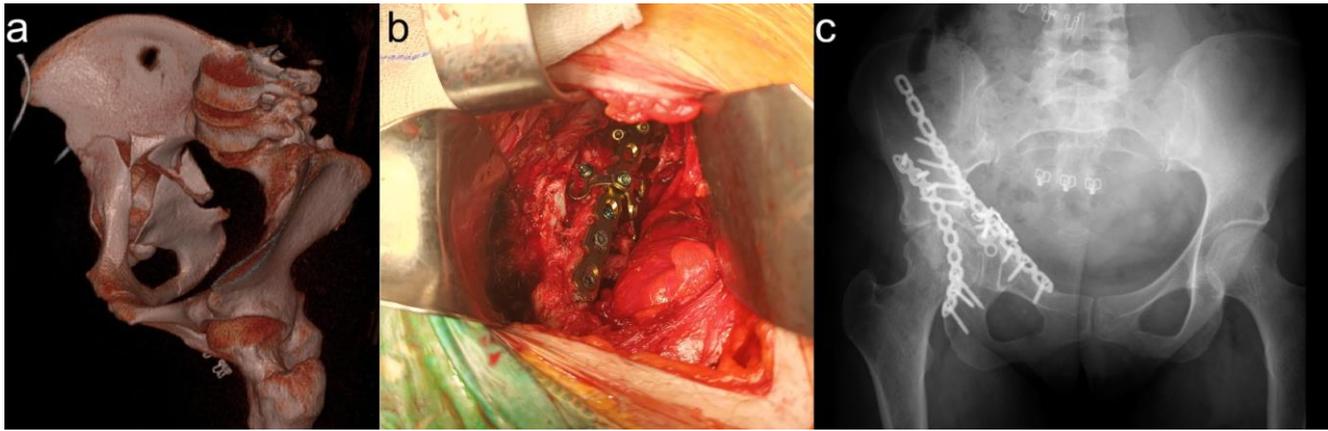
(a) Preoperative 3D computed tomography (CT) imaging of a 29-year-old female patient with a fracture of the right acetabulum and quadrilateral plate. (b) Intraoperative view showing a contoured titanium locking calcaneal plate placed over a suprapectineal reconstruction plate for medial support. (c) Final follow-up radiograph at 1 years postoperatively.
